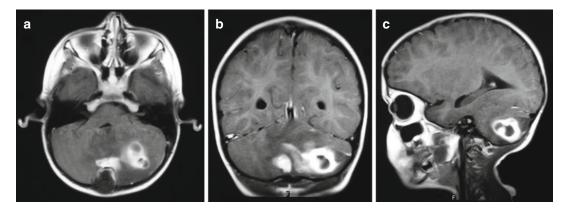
MRI images showing a complicated occipital dermoid at the torcula with associated cerebellar abscess and significant amount of edema involving the cerebellar hemispheres
